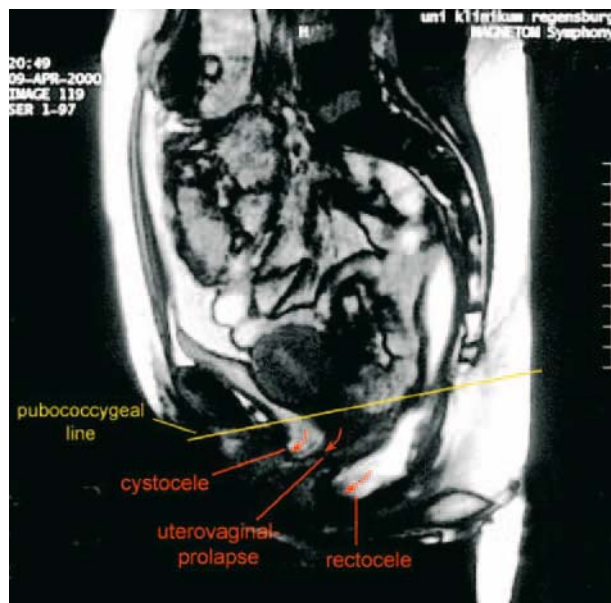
Descending perineum including a cystocele, uterovaginal descensus and rectocele shown by dynamic MRI
